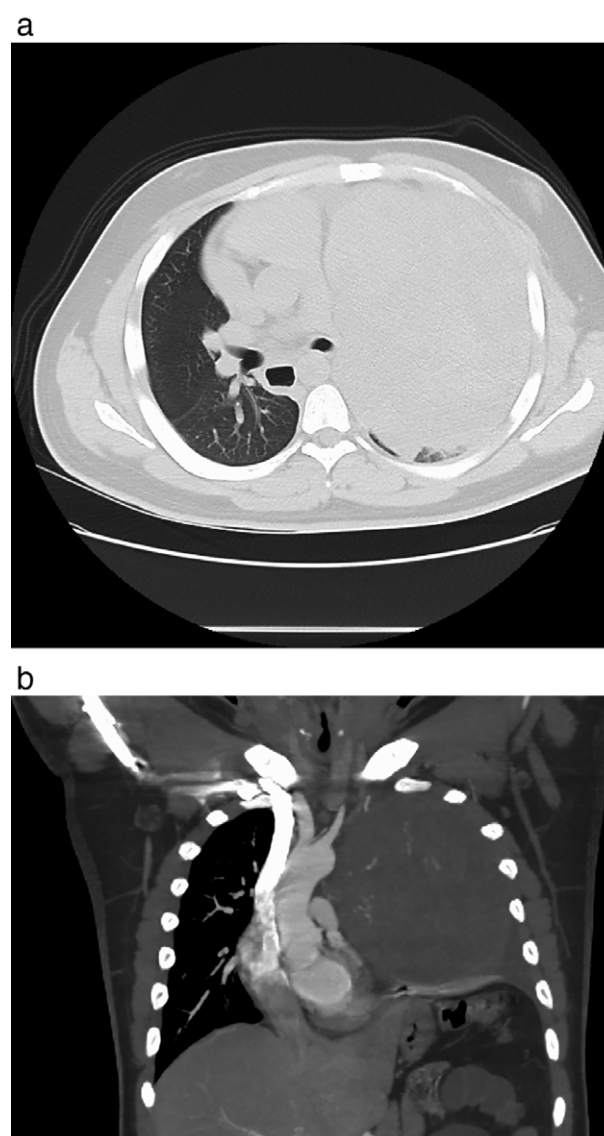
(a) Axial and (b) coronal views of chest contrast enhanced computed tomography image of the huge mass in the left thorax.
